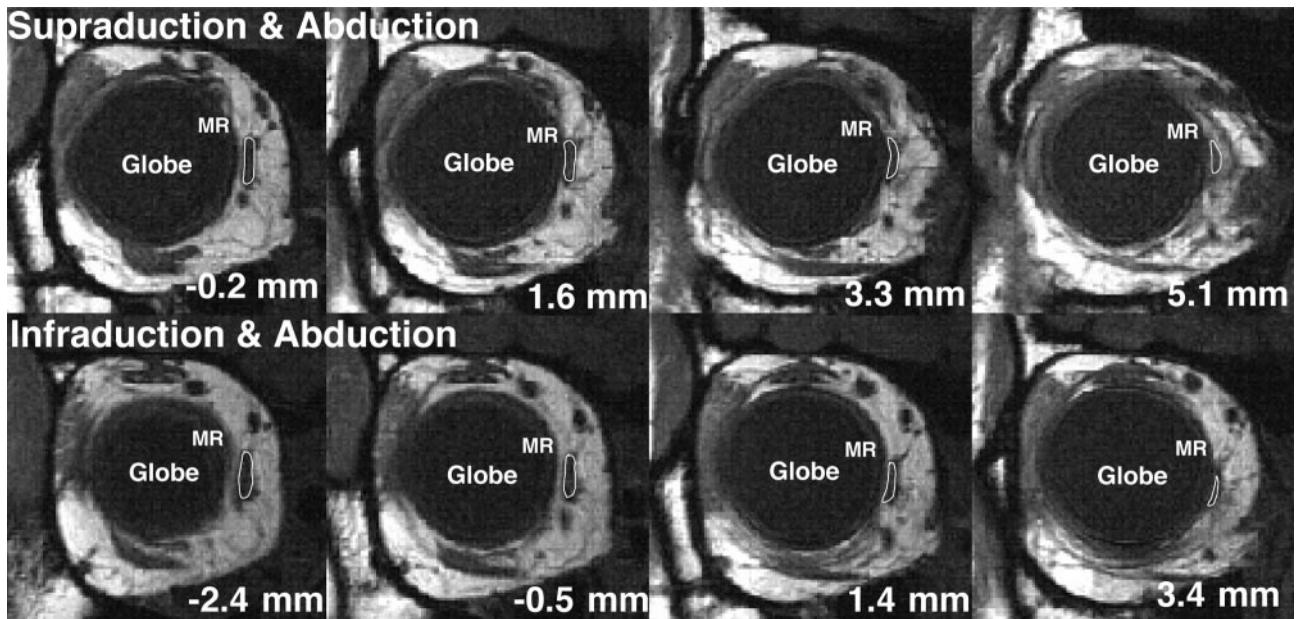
Magnetic resonance images in quasicoronal planes near the globe equator in the tertiary-gaze positions of supraducted abduction and infraducted abduction. The belly and tendon of the MR is outlined in white. The area centroids represent geometric centers of the areas outlined and were used to determine MR path. Numbers indicate the distance anterior to globe center in the normalized coordinate system. Anterior to globe center (right side), images show a superior shift of the MR tendon in elevation, with an inferior shift in depression.
